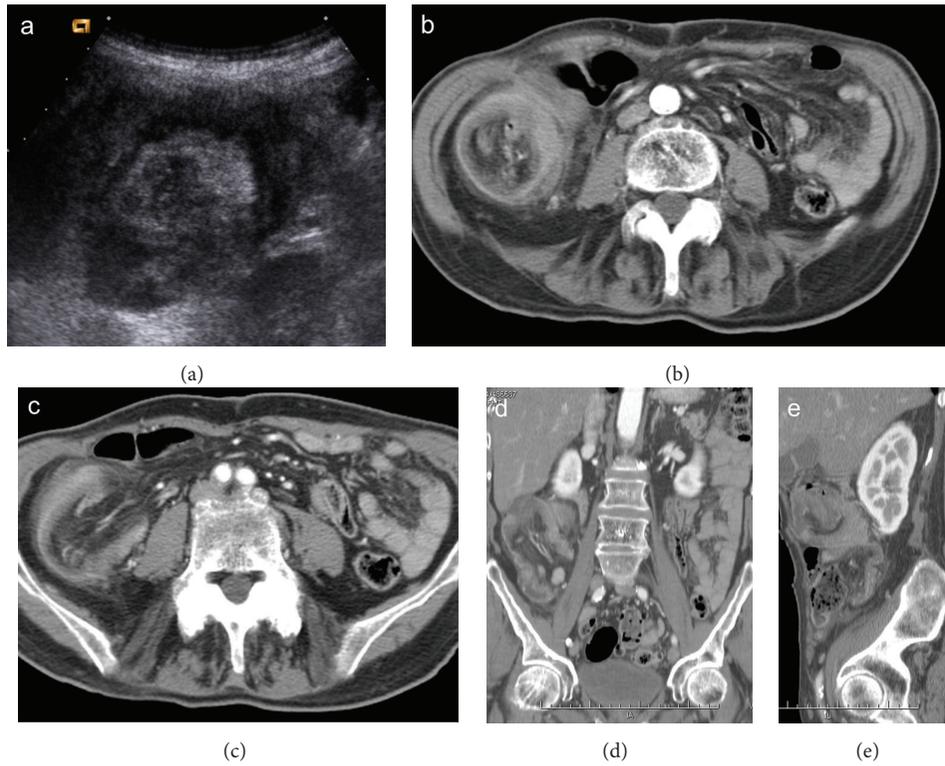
Enterocolic (ileocaecocolonic) intussusception caused by a caecal carcinoma. Ultrasound scan (a) shows a heterogeneous target-like mass located in right flank. CT images on axial scans (b, c) and coronal and oblique reformatting (d, e) demonstrate lead point intussusception with invaginated mesenteric fat, vessels, and lymph nodes.
